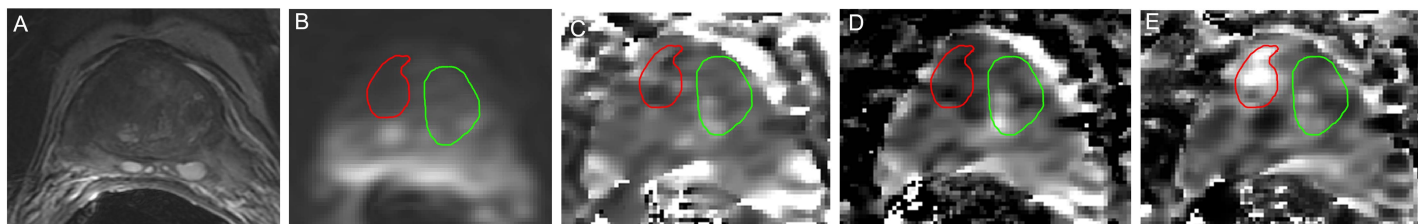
A) T2-weighted image of a 77-year old patient with a PSA level of 13.8 ng/mL and Gleason score 4+3 on biopsy. B) b=0 image with red ROI indicating tumor-suspicious area and green ROI normal appearing TZ. C) Map of ADC_{fast}. D) Map of ADC_{slow}. E) Map of f_{slow}.
